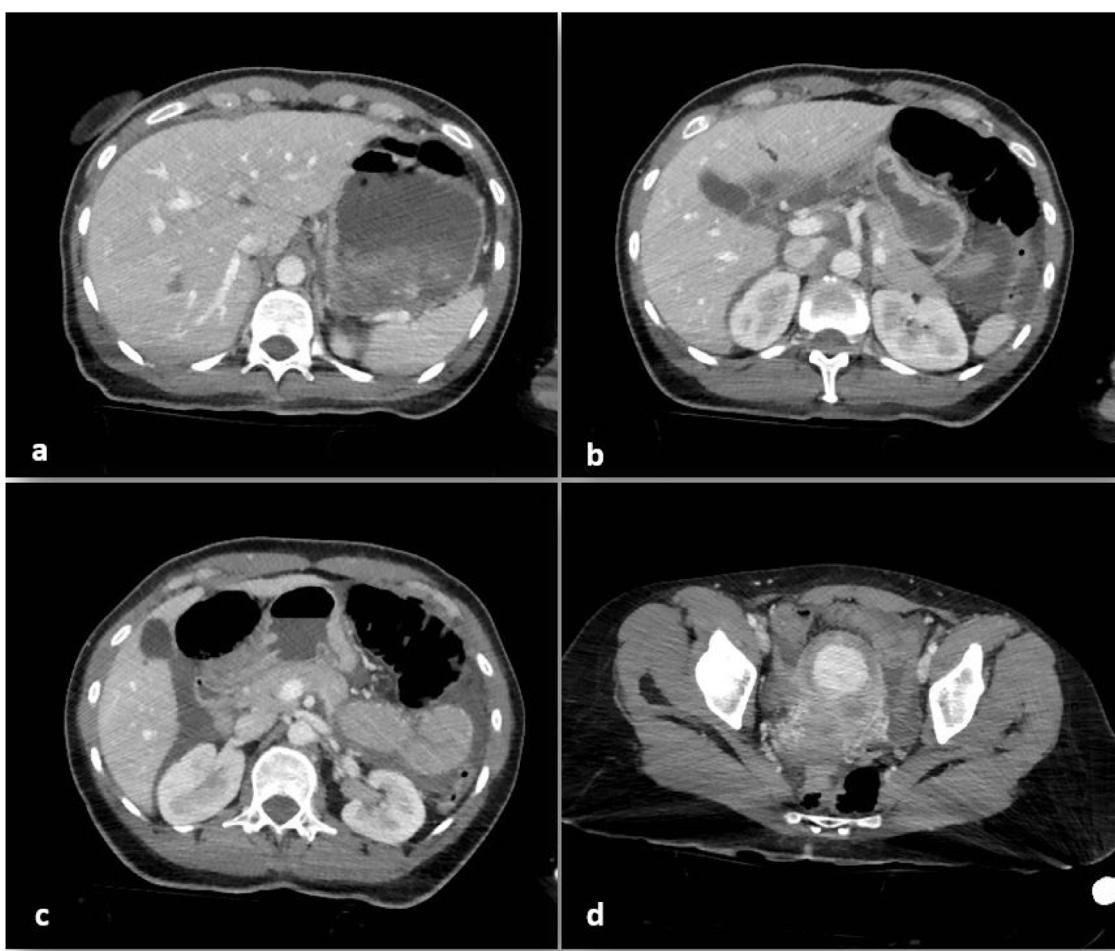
Preoperative CT abdominal scan revealed peritoneal free air and abdominal fluid with siero-hematic characteristics (60 UH). After intra-venous contrast administration we identified a perfusion reduction in the inferior pole of the spleen.
